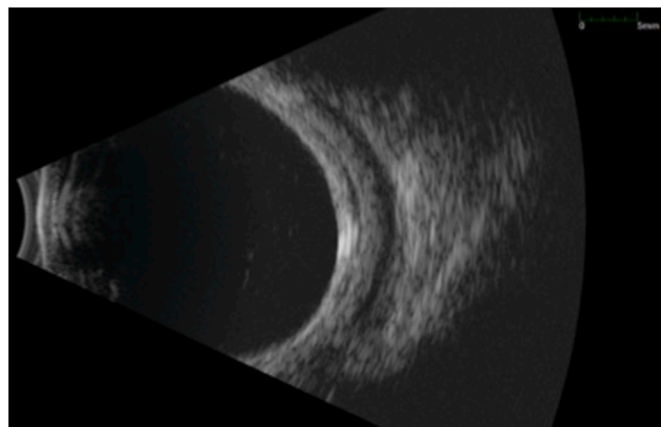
A transverse B-scan ultrasound of the left eye showing a hyporeflective area corresponding to the fluid overlying the Baerveldt glaucoma drainage implant. Notably, there are no signs of posterior scleritis.
